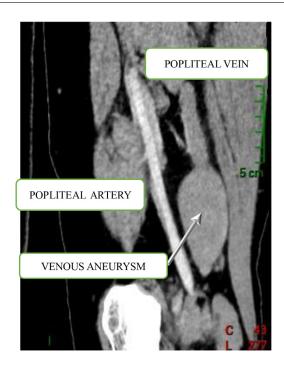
Image of CT angiography of the lower limb arterial and venous phases in the sagittal plane showing the venous aneurysm of the popliteal region.
